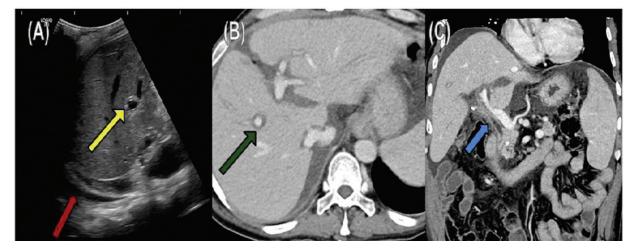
A 41-year-old male patient who underwent liver transplant 2 weeks back, presented with history of fever and elevated bilirubin levels with deranged liver function test (LFT). Ultrasound (USG) abdomen of the liver showed diffuse periportal hyper echogenicity (A, yellow arrow) with mild right pleural effusion (red arrow). Contrast-enhanced computed tomography (CECT) abdomen axial (B) and coronal (C) image of the upper abdomen depicted diffuse intrahepatic periportal hypodensity (green arrow) with diffuse common hepatic duct enhancement (blue arrow) suggestive of periportal edema with cholangitis.
